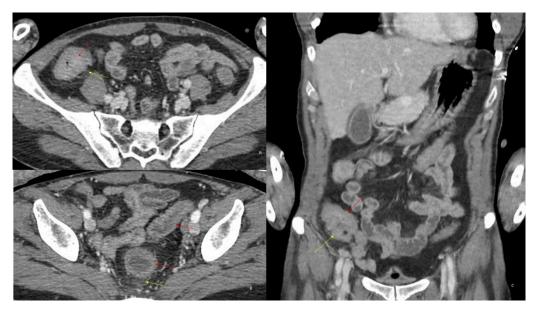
Axial (A and B) and coronal (C) contrast-enhanced abdominal and pelvic computed tomography images demonstrate regular concentric wall thickening involving the colon and the rectosigmoid junction (red arrows) with slightly increased attenuation of mesenteric fat (yellow arrows). Low-grade mural hyperenhancement of the sigmoid colon and rectosigmoid junction is also noted.
